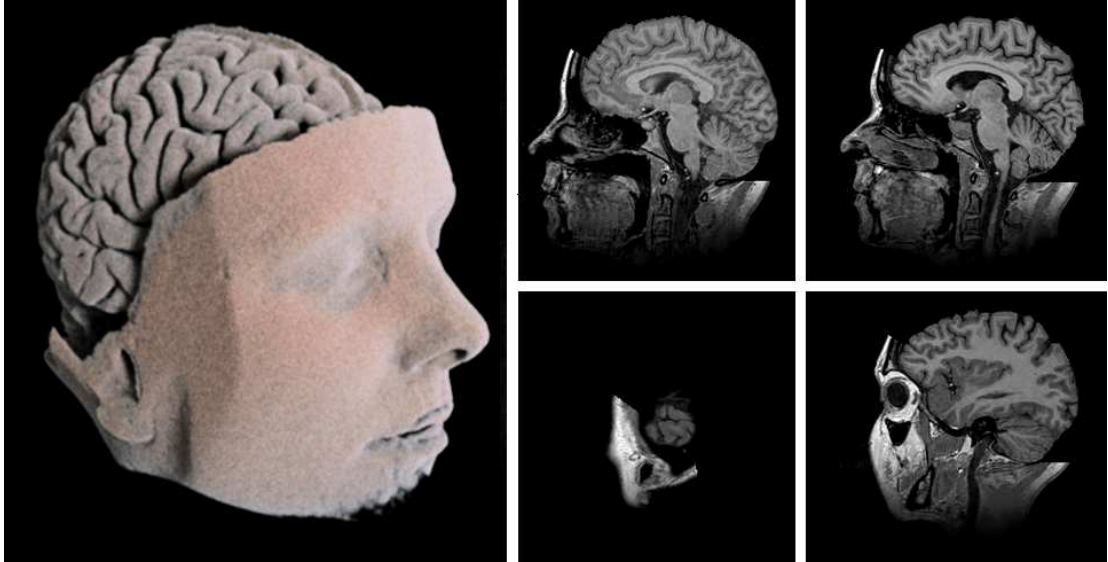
Left: a 3D rendering of the MRI Head dataset [77]. Right: examples of 2D slices from the MRI Head dataset.
